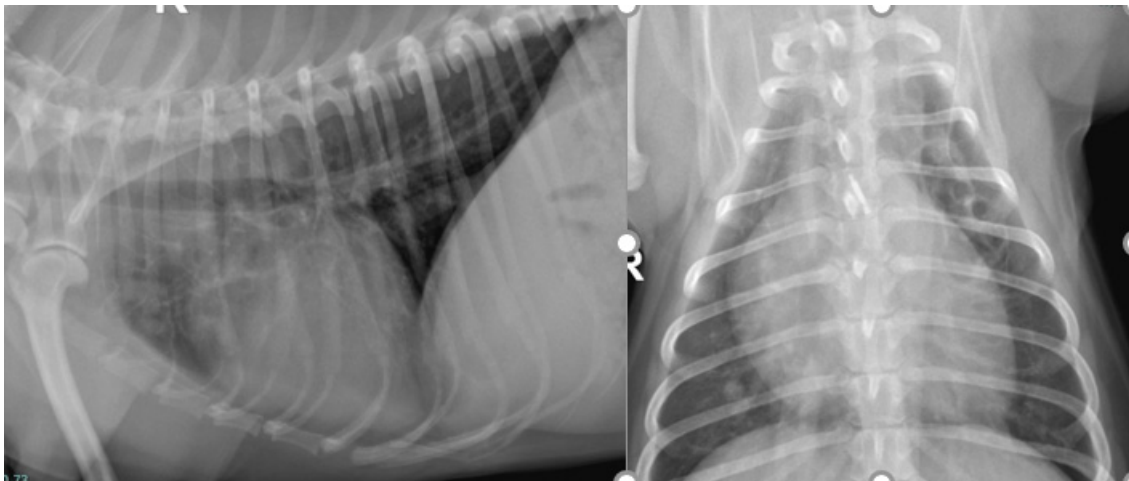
Left lateral and dorsoventral thoracic radiographs 10 weeks following corticosteroid treatment.
